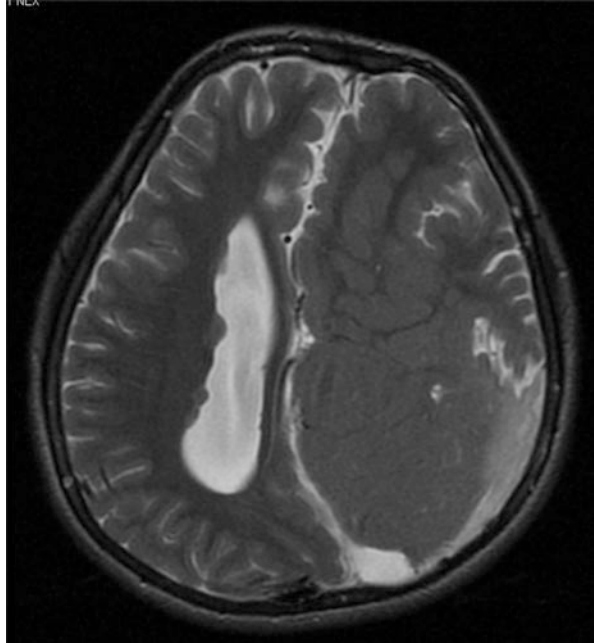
(a) Axial MRI showing left hemimegalencephaly; (b) Axial MRI of that same patient after undergoing functional hemispherectomy
